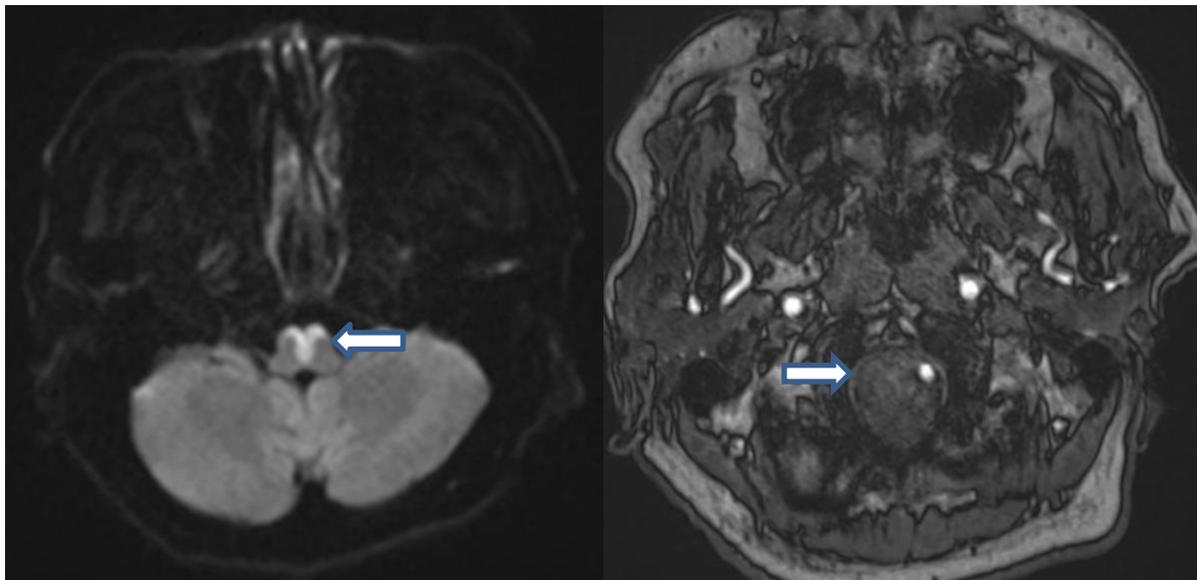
A heart-shaped hyperintense lesion on DWI affecting the bilateral medial medulla ( white arrow). The time of flight image on the right shows a non visualized right vertebral artery ( white arrow).
